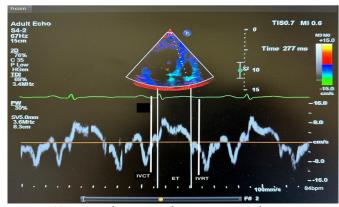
Tissue Doppler imaging demonstrating isovolumic contraction time (IVCT), ejection time (ET), and isovolumic relaxation time (IVRT) in left ventricular systolic function assessment
